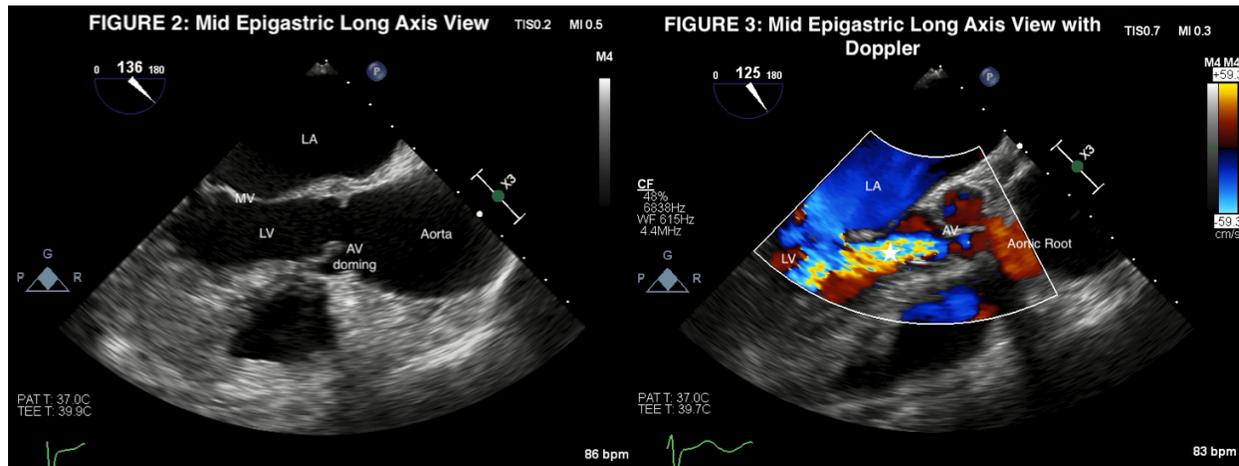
to 3: Mid Epigastric Long Axis View. In *figure 2*, aortic valve doming is seen during mid systole, suggesting asymmetry and restriction. In *figure 3*, taken with doppler ultrasonography during mid diastole, a “mosaic pattern” (*star*) is evident in the left ventricular area, suggesting aortic regurgitant flow
